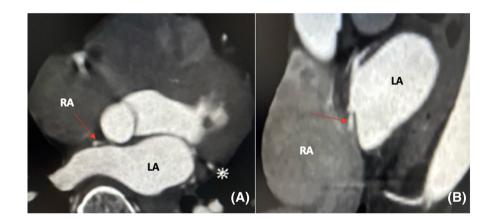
Patent foramen ovale (PFO) on CT. (A) Image shows a subtle thin contrast-filled channel (red arrow). (B) This sagittal image better shows the communication between the left atrium (LA) and right atrium (RA) through a defect at the fossa ovalis (red arrow) consistent with a PFO.
